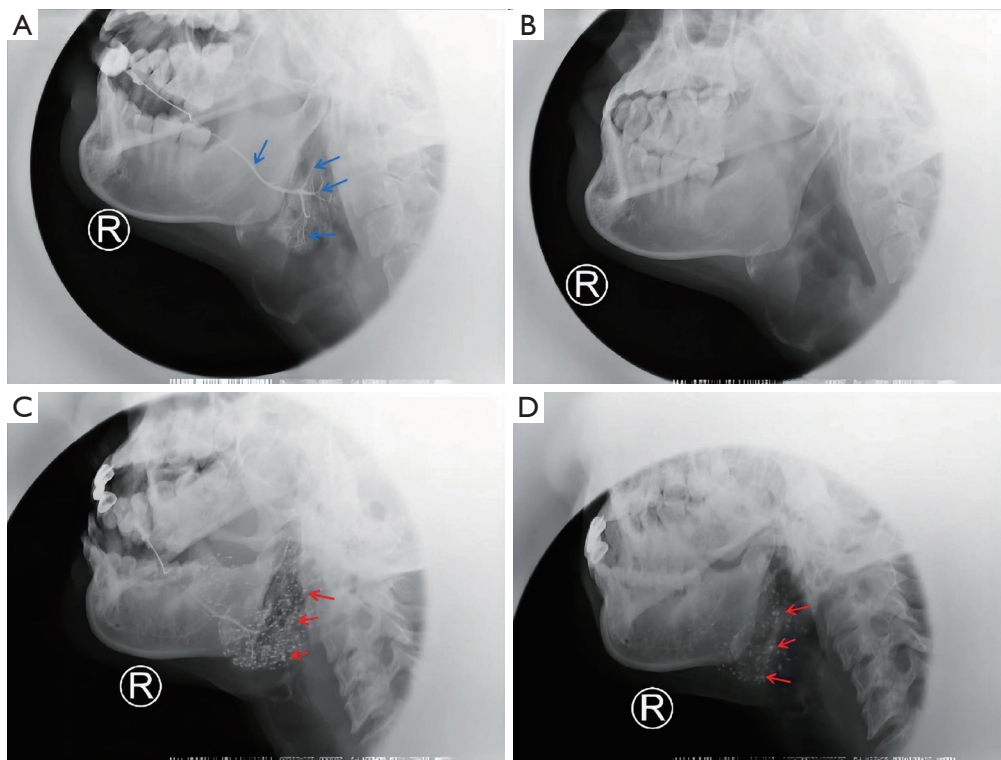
Radiographic manifestations in pSS patients. Mild-type manifestation in a 34-year-old male pSS patient: (A) the contrast phase showed that the main duct and its branches gradually became thinner with a natural course and smooth duct wall, similar to leaf veins. Blue arrows: main duct and its branches. (B) The emptying phase showed substantial emptying of the contrast in the main duct and its branches. Severe-type manifestation in a 48-year-old female pSS patient: (C) the contrast phase showed multiple punctate and globular sialectasis of terminal ducts. Red arrows: multiple punctate and globular sialectasis of terminal ducts. (D) The emptying phase showed delayed emptying with residual contrast in terminal ducts. Red arrows: residual contrast in terminal ducts. pSS, primary Sjögren's syndrome.
